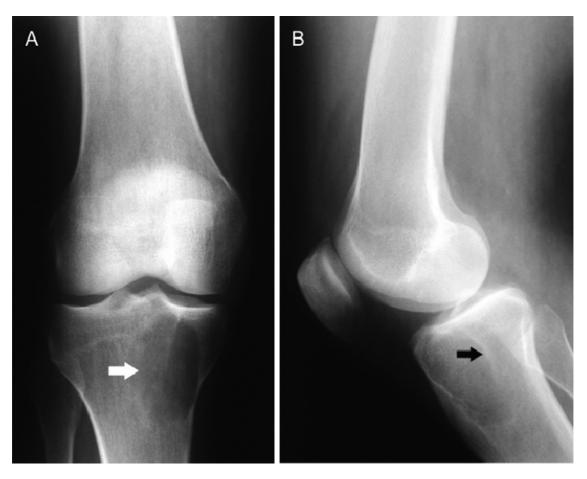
(A) The AP radiograph shows a 5 cm, eccentric lytic lesion (white arrow) in the proximal tibia, centered in the lateral aspect of the metaphysis but extending into the epiphysis, close to the articular surface. (B) The lateral view shows a curvilinear area of calcification projected over the posterior aspect of the lesion (black arrow) representing pseudotrabeculation due to endosteal scalloping.
